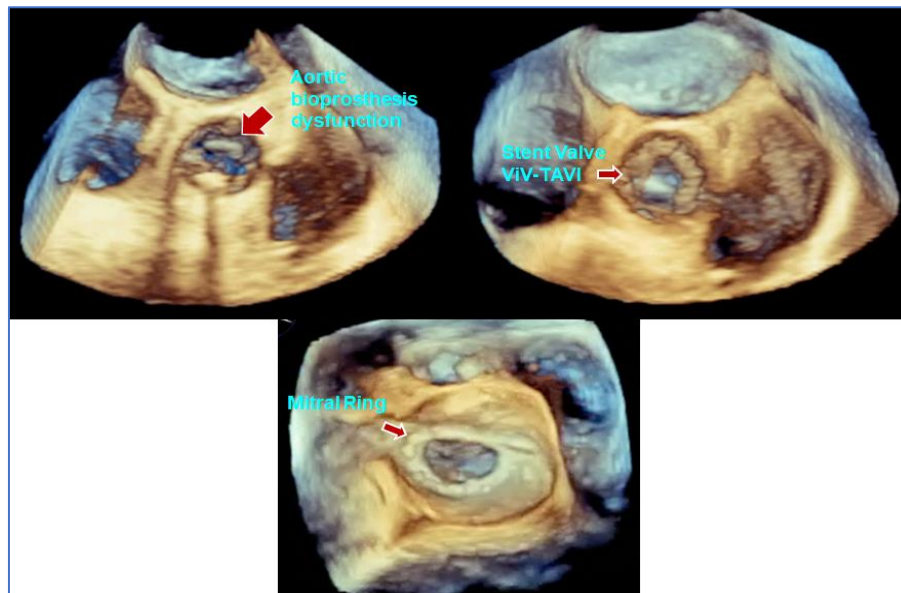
Postoperative Three-dimensional echocardiographic images show competent stent-valve
